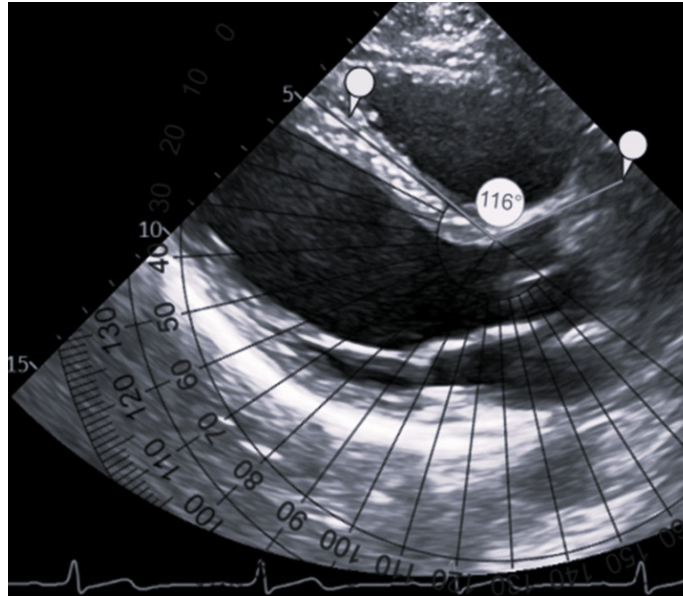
Measurement of aortoseptal angle in 2D echocardiography.
